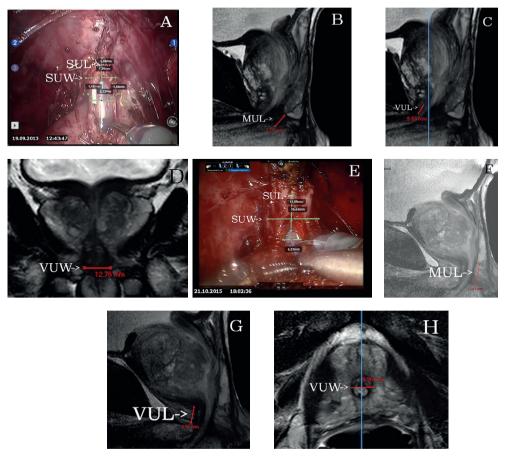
(A,E) Measurement of the SUL and SUW using Kinovea software in a incontinent (A) and continent (E) patient; (B-D) measurement of the MUL (B), VUL (C) and VUW (D) on the MRI images of a incontinent paten; (F-H) measurements of the MUL (F), VUL (G) and VUW (H) on the MRI images of a continent patient.
